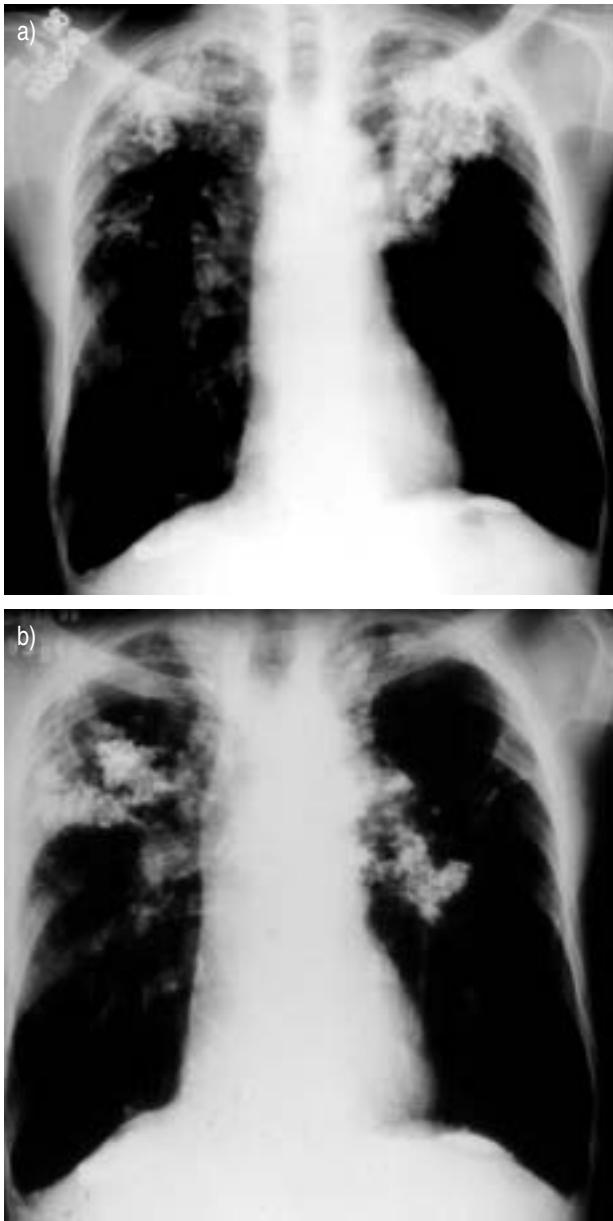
a) Postero-anterior chest radiograph showing calcified coalescence areas in upper lobes, lung hyperinflation, bilateral eggshell lymph nodes, and calcified diaphragmatic pleural plaques. b) Chest radiograph, performed 3 yrs later, showing gradual reduction of calcified opacities.
